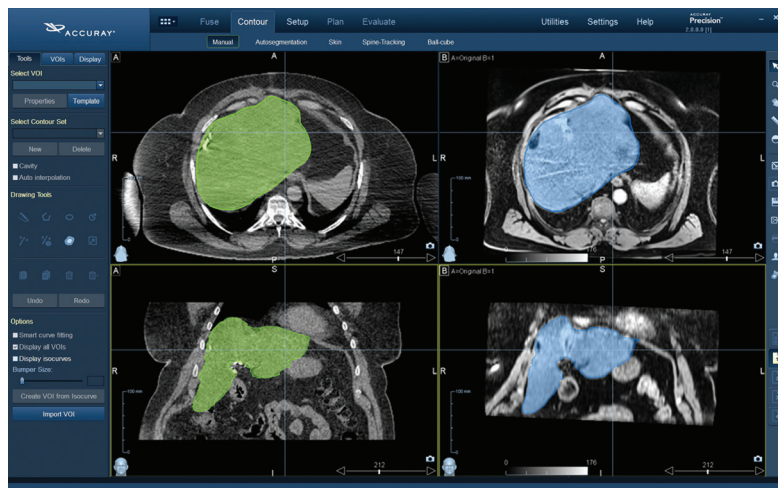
Example of liver ground-truth contours. Contours drawn on CT shown in green (left), contours drawn on MR shown in blue (right).
